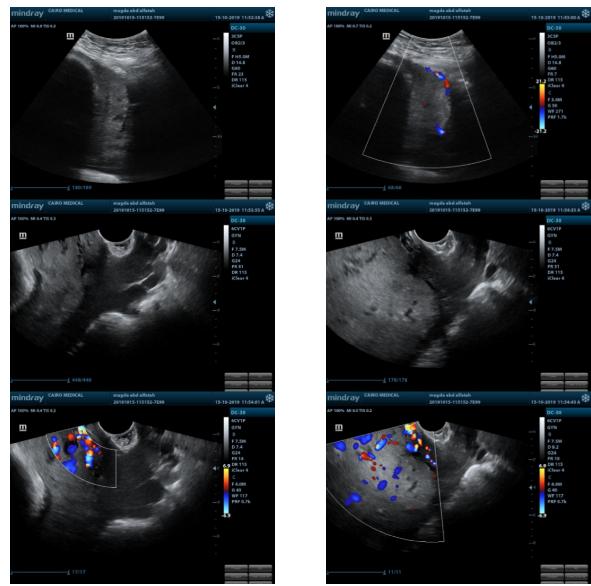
Ultrasound imaging of case 3
